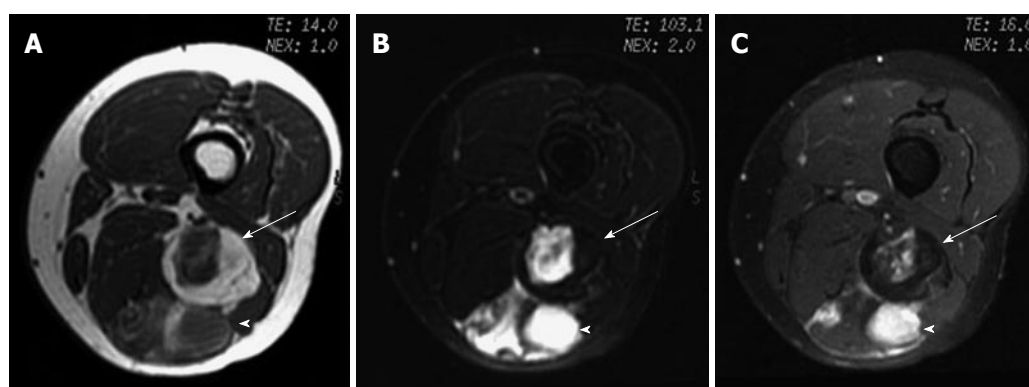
Myxoid liposarcoma. A: Axial T1-weighted image; B: Fat-saturated T2-weighted MR image; C: Fat saturated gadolinium-enhanced T1-weighted images of left thigh show a lobulated fat-containing mass (arrow) with an enhancing nonadipose mass-like area (arrowhead) on the left thigh, suggestive of myxoid stroma.
